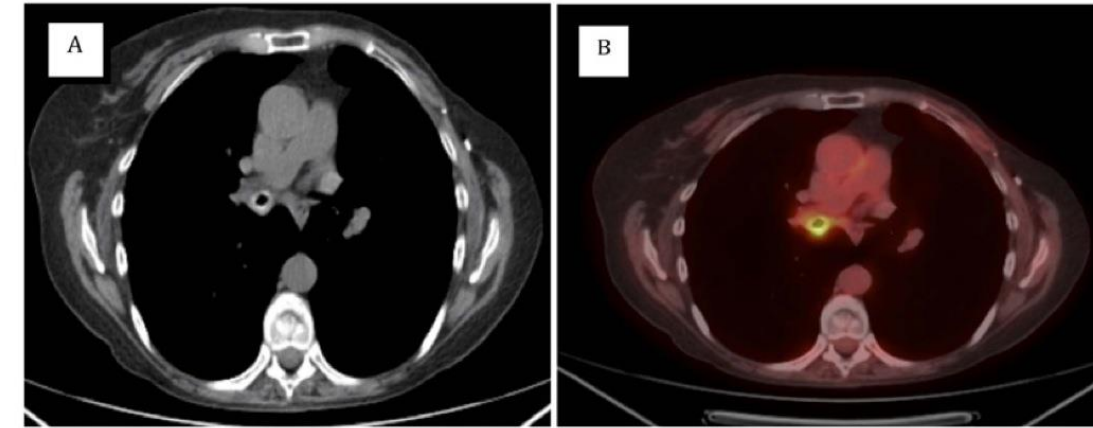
(A) Computed tomography image with circumferential thickening of the bronchus intermedius. (B) Positron emission tomography–computed tomography image with circumferential fluorodeoxyglucose-avid area of the bronchus intermedius.
